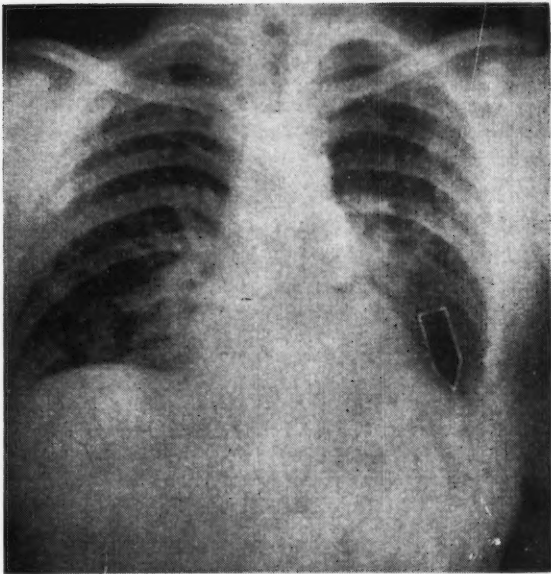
Chest x-ray; basal pleuritis without associated rib fracture; splenic rupture occurring two days later.
